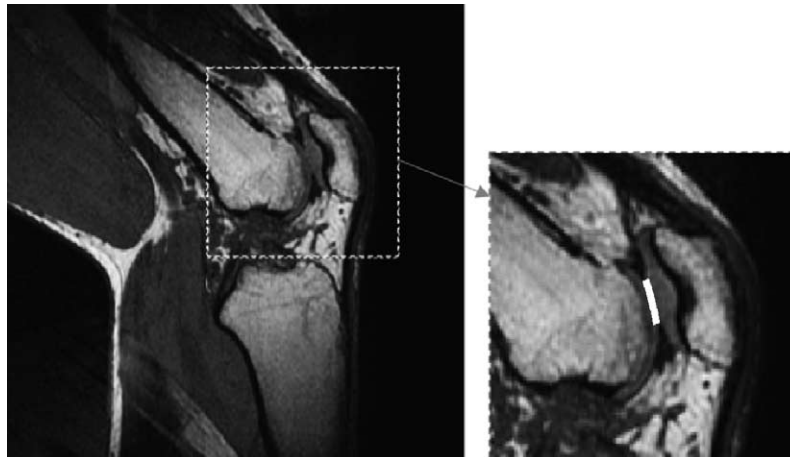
Typical sagittal MR image used to calculate contact area. Zoomed view shows the region of contact between the femur and patella that was manually defined.
